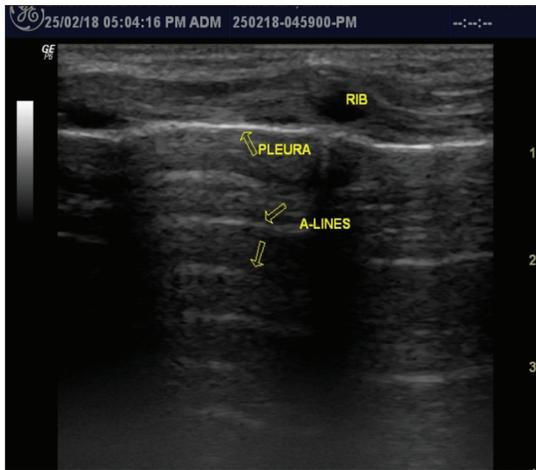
Transverse lung ultrasound scan using curvilinear transducer showing the normal lung, pleural line and A-lines
